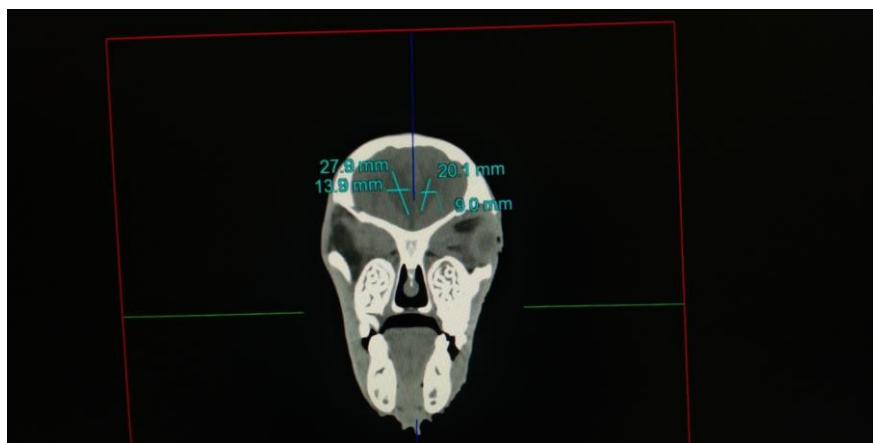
CT scan coronal section of calf head showing enlarged ventricles with height and length measurement
